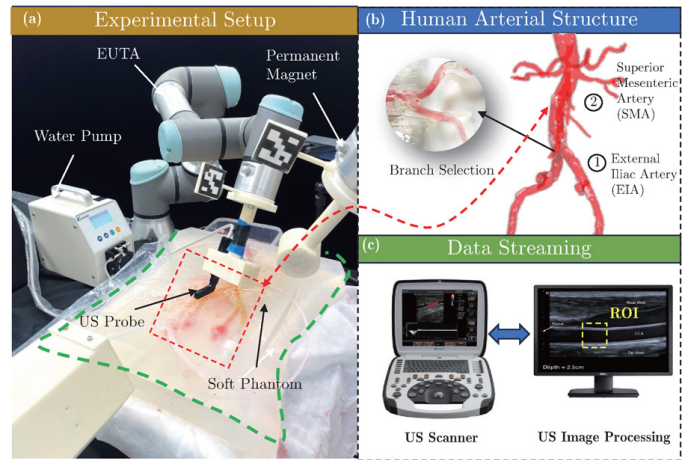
The experimental setup for the magnetic catheterization with ultrasound guidance.
